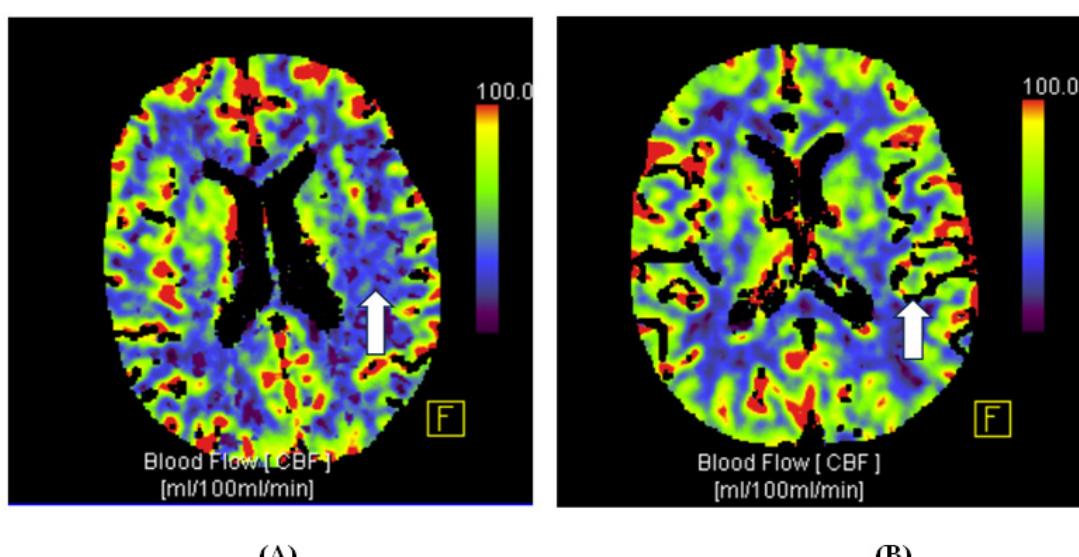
Preoperative brain perfusion computed tomography; White arrow shows the frontoparietal hypoperfusion area.
